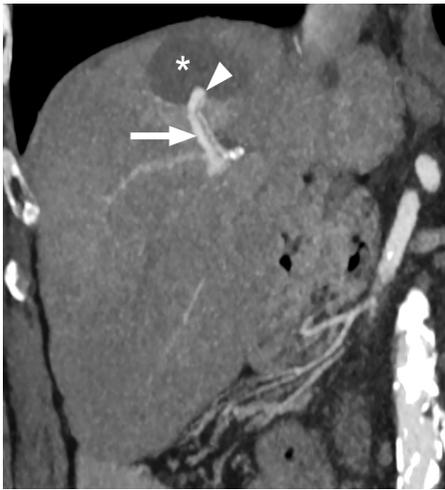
Arterioportal fistula (APF) formation after microwave ablation of a segment 8 hepatocellular carcinoma. Coronal maximum intensity projection contrast-enhanced computed tomography image in the arterial phase displays the APF (arrowhead) with early opacification of the adjacent segmental portal vein (arrow). Note the ablation zone (asterisk).
